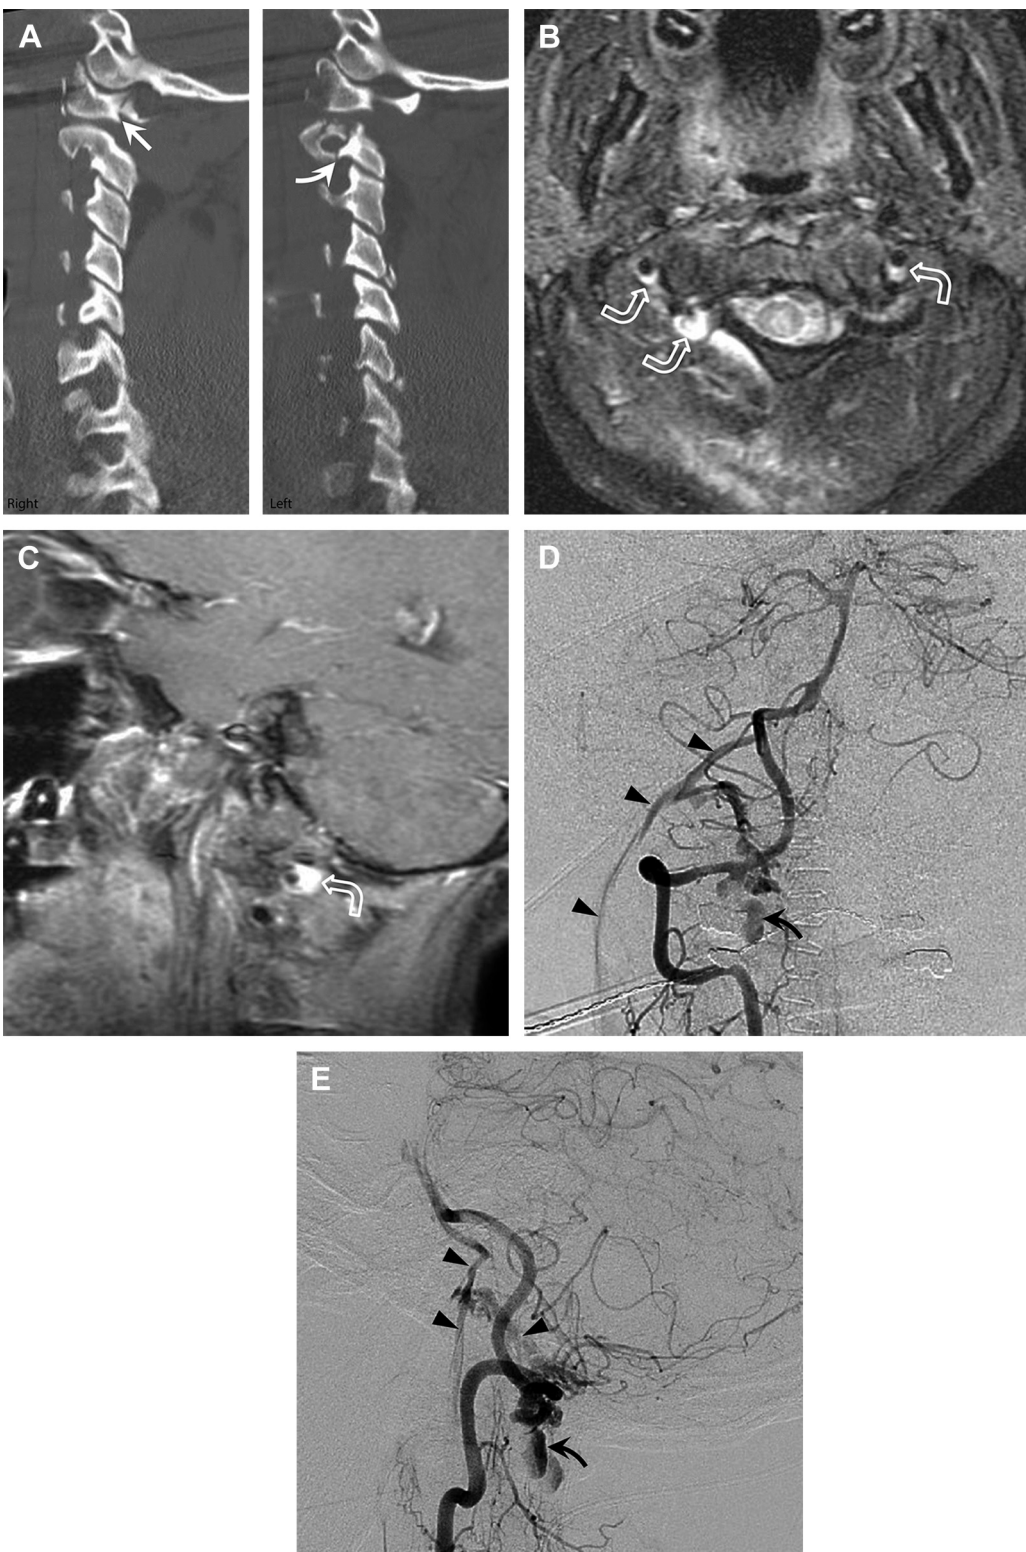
Partial right vertebral artery transection and vertebral artery-venous fistula. (A) Bilateral sagittal CT images demonstrate fractures of the right C1 posterior arch (*white arrow*) and left C2 foramen transversarium (*curved white arrow*), both of which are known high-risk radiographic findings for BCVI. Axial (B) and right sagittal (C) T1-weighted fat-suppressed contrast-enhanced MR images reveal areas of intramural contrast extravasation (*curved white arrows*) at sites of vascular injury. Lateral (D) and anteroposterior (E) angiogram images reveal early entry of contrast into the perimedullary venous plexus (*arrowheads*), confirming an arteriovenous fistula. Additionally present are free contrast extravasation and loculated collections of contrast (*curved arrow*) within the paravertebral soft tissues, representing a Denver grade 5 injury.
